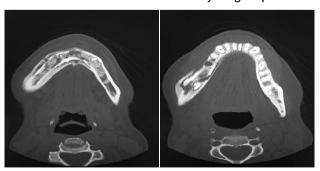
Non contrast CT scan axial view of face, showing patchy areas of sclerosis and lucencies involving mandible.
